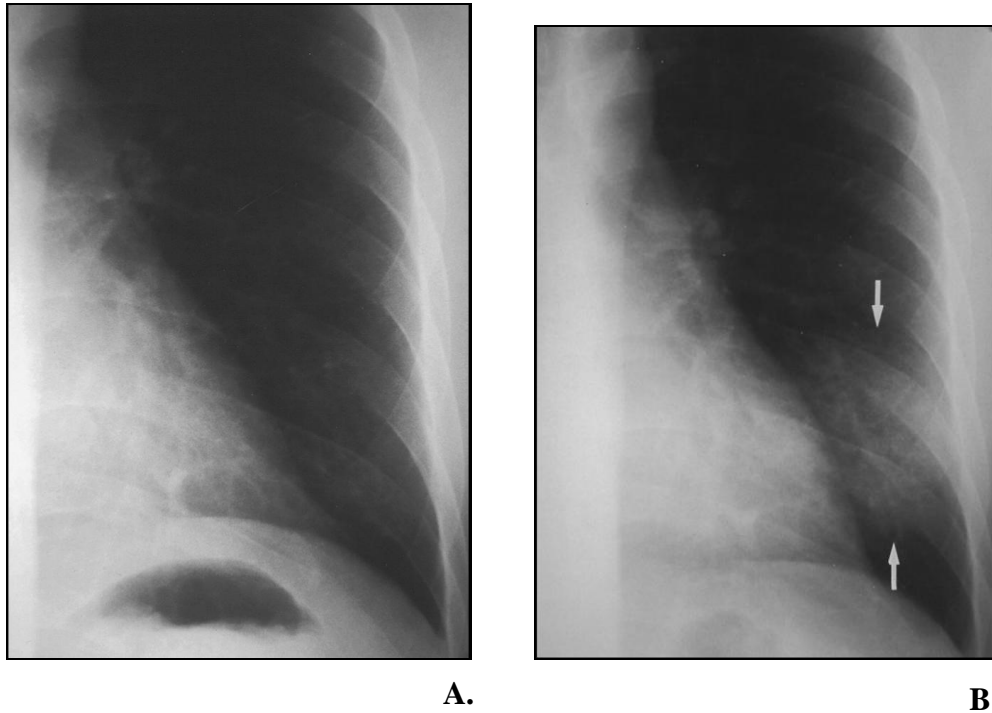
31-year-old man who presented with fever, chills, cough and diarrhea. (A) Left lower lung zone on initial chest radiograph is normal. (B) Chest radiograph obtained three days after initial symptoms shows air-space consolidation at left lower lung zone (arrows).
